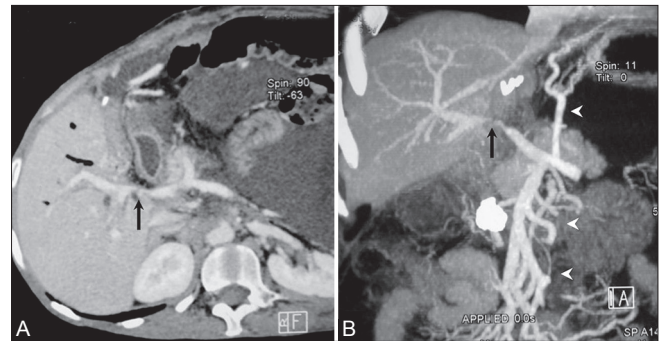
(A, B): (A) Curved reconstruction of CT scan showing short segment narrowing of main portal vein (arrow) without residual or recurrent mass. Ascites is also noted. (B) Maximum intensity projection image showing the stenosis (arrow) with multiple collaterals (arrow heads)
